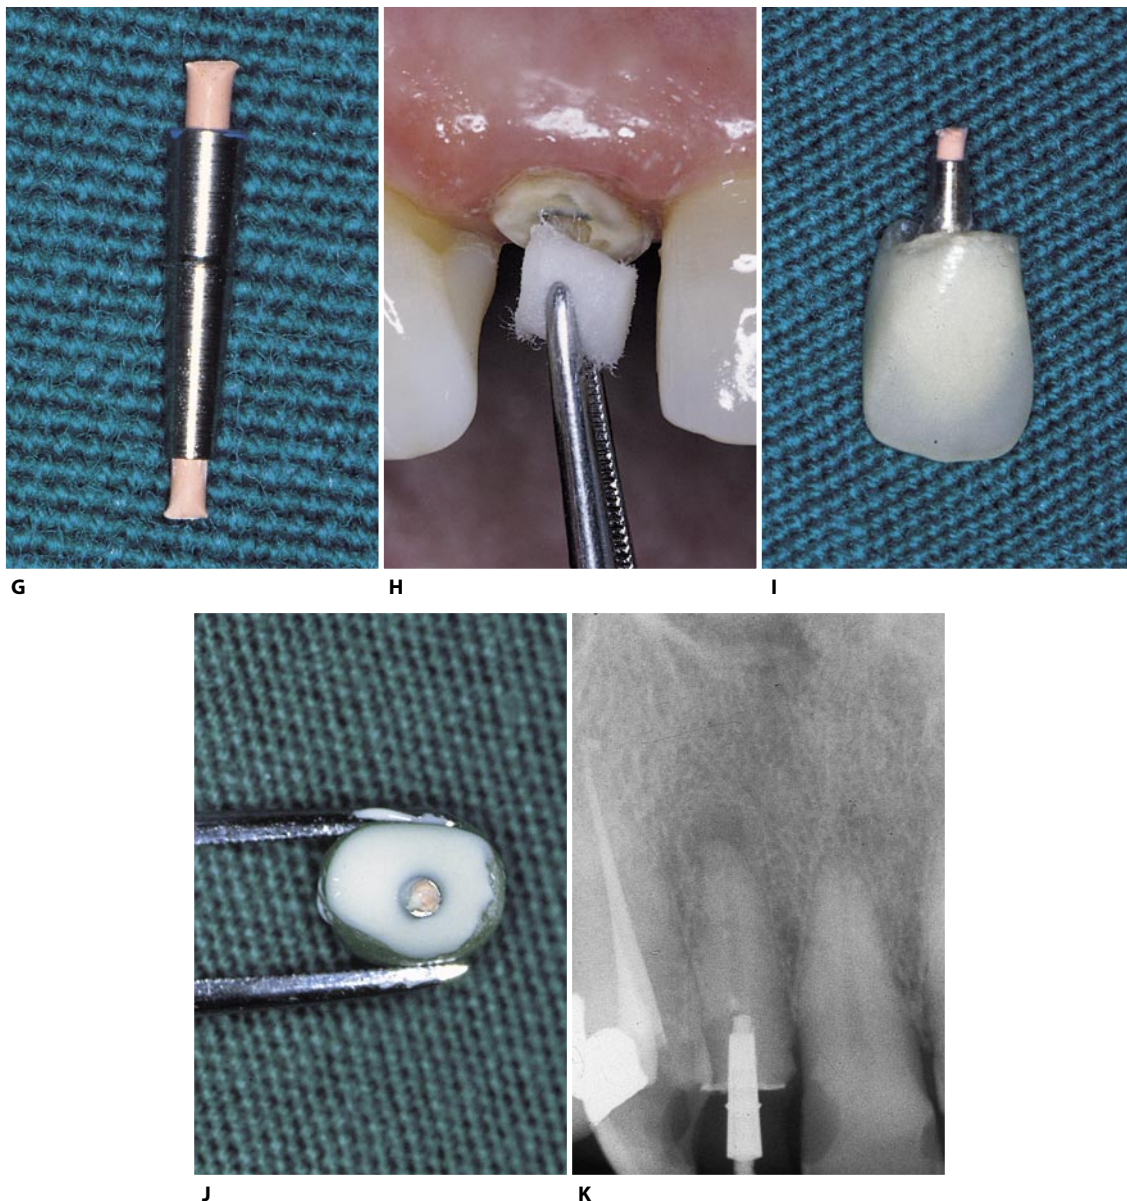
(continued) G. The hollow post before re-lining and cementation of the temporary crown. Note that the gutta-percha cone is encased in the resin; this not only helps in finding the access cavity but in preventing obstruction of the root canal by the definitive cement. H. The abutment is lubricated with paraffin oil before re-lining of the temporary crown. I. The temporary crown previously made in the laboratory has been re-lined with the hollow post encased within. J. The temporary crown filled with oxyphosphate cement ready for cementation: note the gutta-percha cone within the hollow post. K. Radiograph at completion of cementation (continued).
